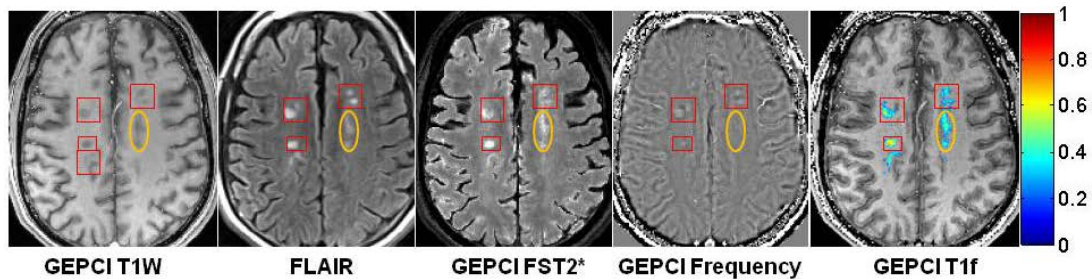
Example of data obtained from a subject with RRMS (male, age 52, EDSS 3.5) showing multiple lesions (red rectangles) with intermediate TDS scores (overlaid on GEPCI T1f image). Here, lesions seen on FLAIR are also seen on GEPCI T1W, GEPCI FST2* (GEPCI analog of FLAIR) and GEPCI Frequency map. Area within orange oval also corresponds to intermediate TDS with low phase contrast.
